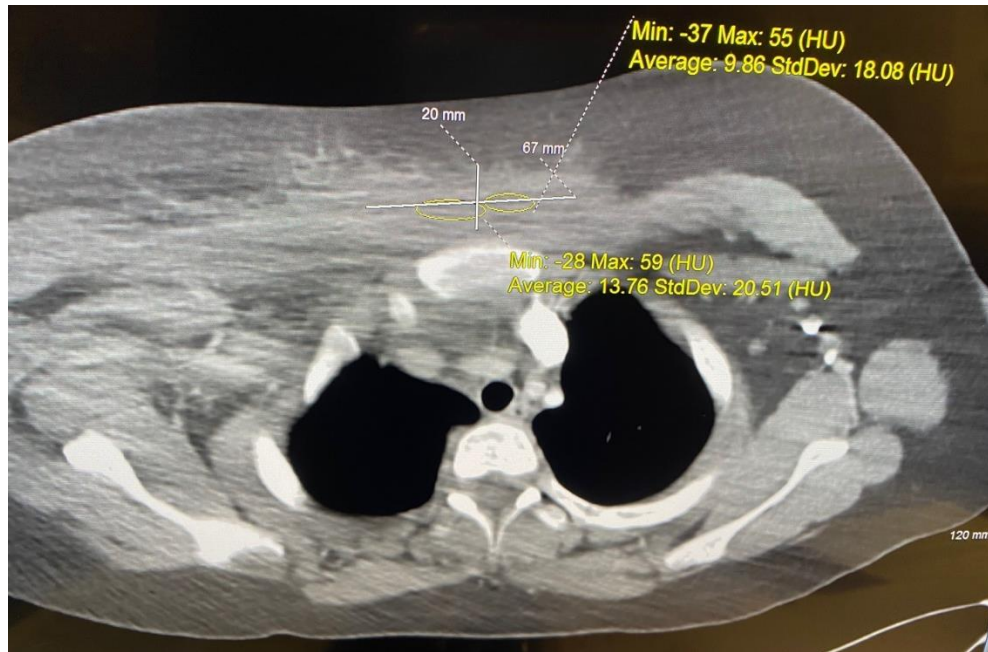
Transverse CT with contrast
